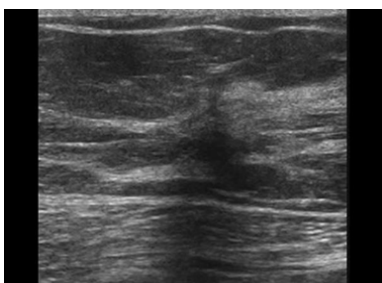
Ultrasound showing spiculated lesion with posterior shadowing in a case of radial scar.
